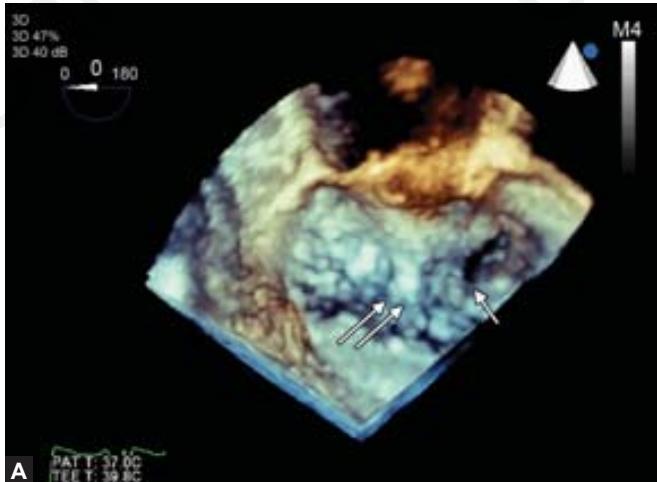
Two examples highlighting utility of three-dimensional transesophageal echocardiography in the assessment of mitral valve pathologies. A, There is perforation in the A3 segment (single arrow) and prolapse of the A2 segment; B, A1 P1 segments are flail with perforation in A1 (arrow).
